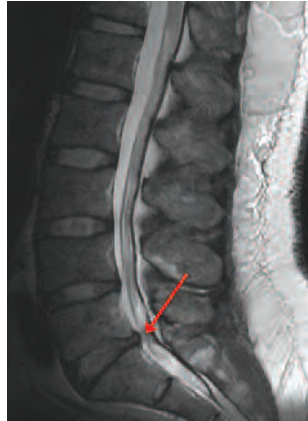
Sagittal T1-weighted MRI of the lumbar spine, without contrast, showing a posterolateral disc bulge at L5/S1.
